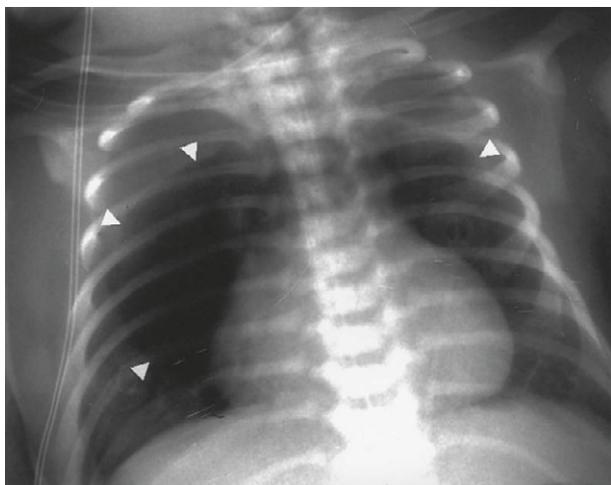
At 2 days of age, anteroposterior chest roentgenogram revealed a wide radiolucent area over the mediastinum (arrowhead).
